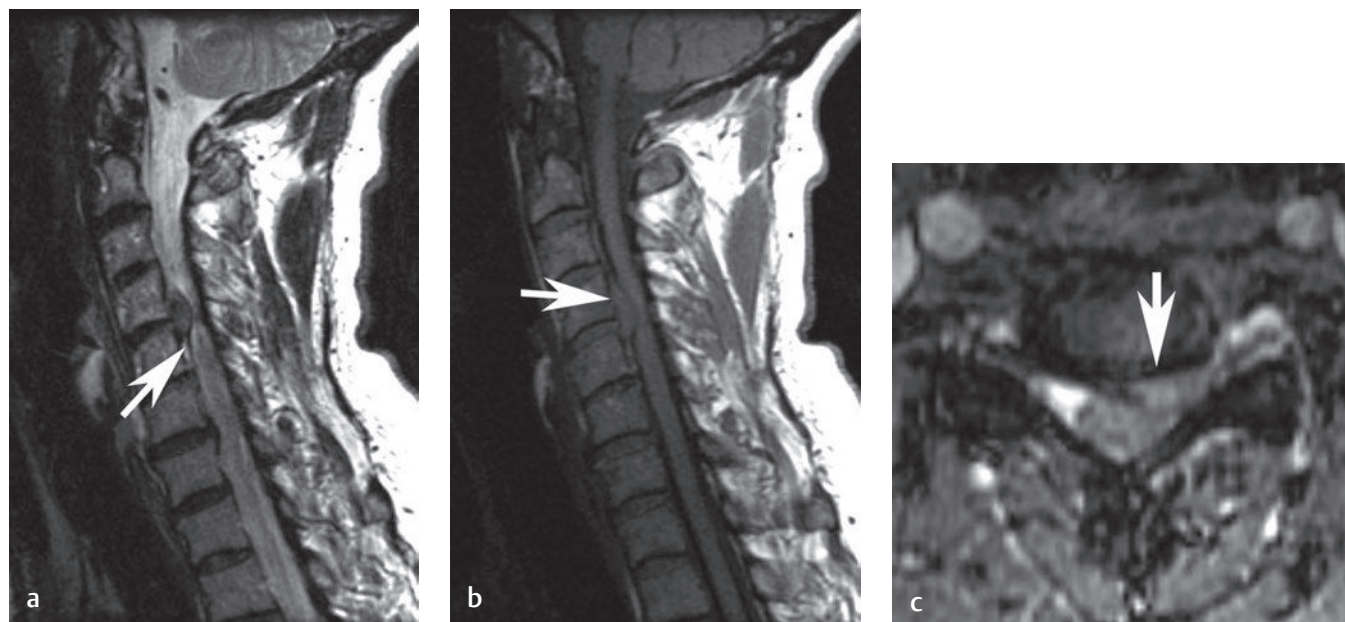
Cervical disc extrusion. (a) A sagittal T2-weighted image shows a large disc extrusion at the C4-C5 level (arrow) that has migrated proximally, tenting the posterior longitudinal ligament. (b) A sagittal T1-weighted image shows the disc extrusion at the C4-C5 level (arrow) that is isointense to the intervertebral disc. (c) An axial T2-weighted image shows a left paracentral disc extrusion (arrow), which produces severe foraminal stenosis and deformity on the left side of the cord.[†]
